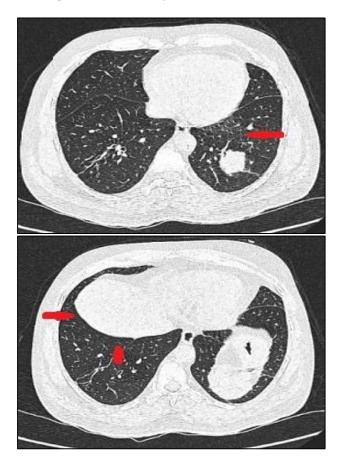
HRCT thorax showed basal atelectasis on right side with eventration of left dome of diaphragm.
